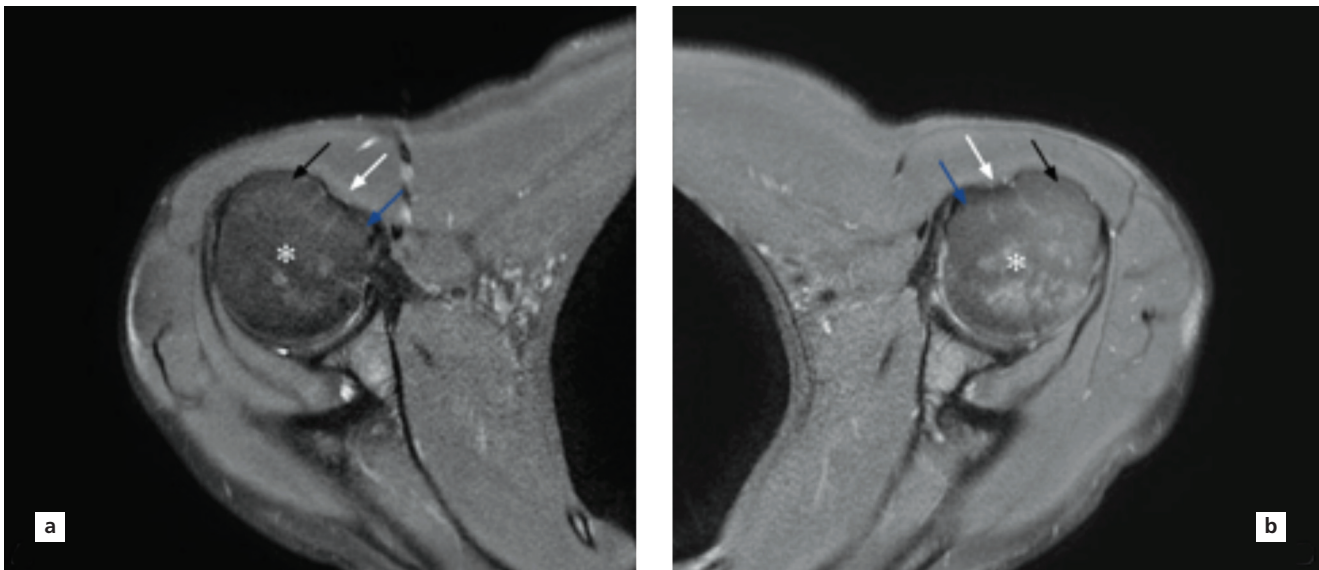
Axial fat suppressed proton-density weighted MR images. (a) right; (b) left shoulders. Biceps long head tendon is not observed, intertubercular sulcus is shallow (white arrow). Asterisk: head of humerus; black arrow: greater tubercle of humerus; blue arrow: lesser tubercle of humerus.
